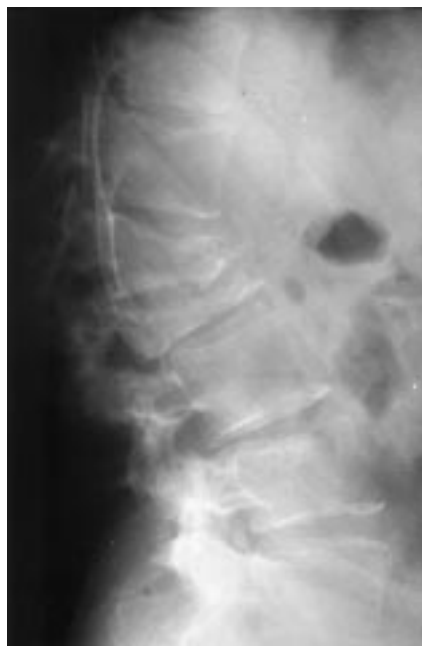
Radiograph of a 66-year-old woman with known breast cancer and scintigraphically demonstrable metastases to T-11 and T-12. Although the wedge compression fractures demonstrated presumably are secondary to metastases, their appearance on plain radiography is indistinguishable from that of benign pathologic fractures secondary to osteoporosis.
